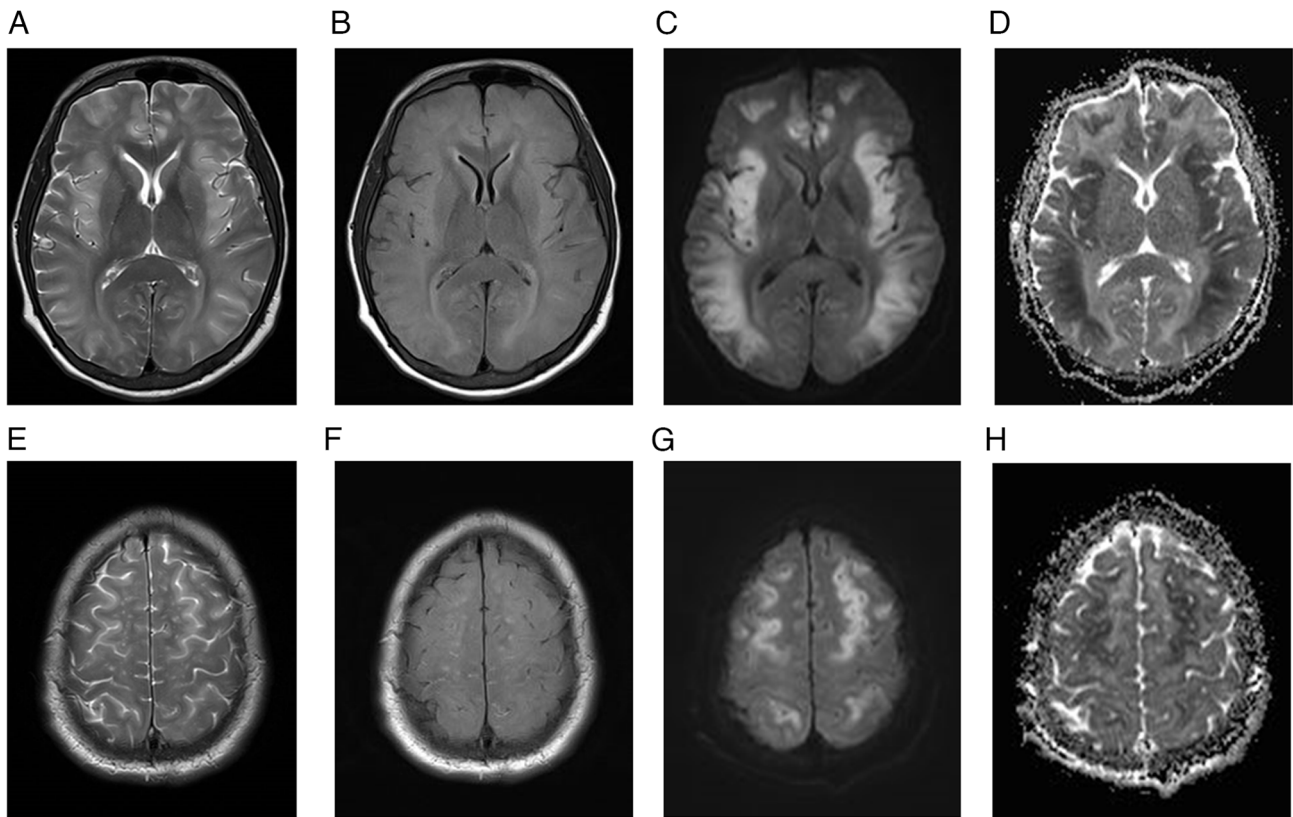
MRI brain scan for case 3. (A) T2-weighted MRI, (B) FLAIR, (C) DWI and (D) ADC map demonstrating symmetric cortical swelling with high T2 and FLAIR signal intensities involving the bilateral insular cortex, frontal lobes, temporal lobes, parietal lobes, cingulate gyri and bilateral lateral thalami, with corresponding diffusion restriction. The bilateral occipital lobes are spared. At the level of the vertex, (E) T2-weighted MRI, (F) FLAIR, (G) DWI and (H) ADC map demonstrating similar symmetric cortical swelling with high T2 and FLAIR signal intensities affecting the frontal and parietal lobes, with corresponding restricted diffusion. The bilateral peri-rolandic regions are spared. MRI, magnetic resonance imaging; FLAIR, fluid attenuated inversion recovery; DWI, diffusion-weighted imaging; ADC, apparent diffusion coefficient.
